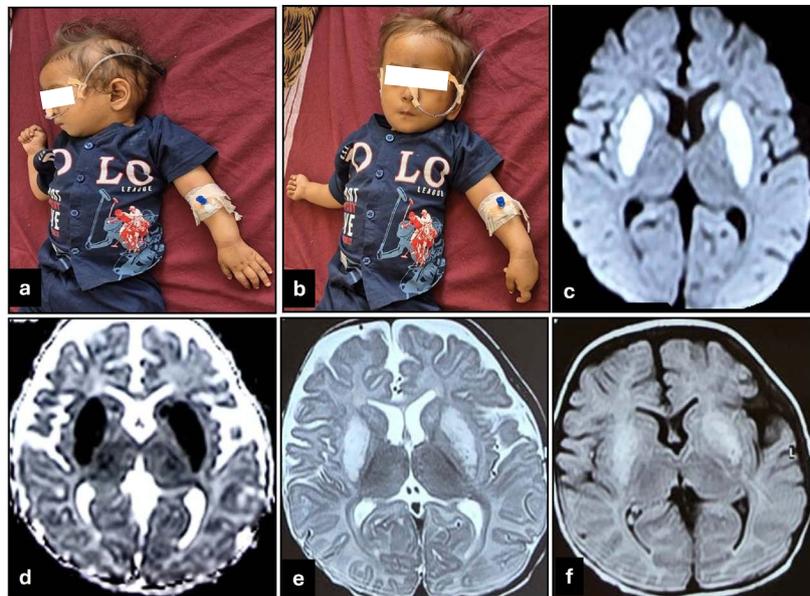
An 8-month-old infant with recurrent vomiting, regurgitation of feeds, and encephalopathy of subacute onset. Irritability reduced on day 3 of treatment; however, persistent oral dyskinesia compelled the need for naso-gastric feeds. Typical cortical fisting, limb dystonia with intermittent neck extension and arching were noted along with hypopigmented sparse hairline representing micronutrient deficiency (a and b). On neuroimaging, axial DWI (c) showed bilateral symmetric areas of diffusion restriction in the Putamen and caudate with signal drop in corresponding areas in ADC (d), suggestive of acute cytotoxic striatal injury. Axial T2WI and T2-FLAIR (e and f) depict diffuse frontotemporal cerebral atrophy with bilateral symmetric homogenous hyperintense signal changes in the putamen in T2-FLAIR(f).
